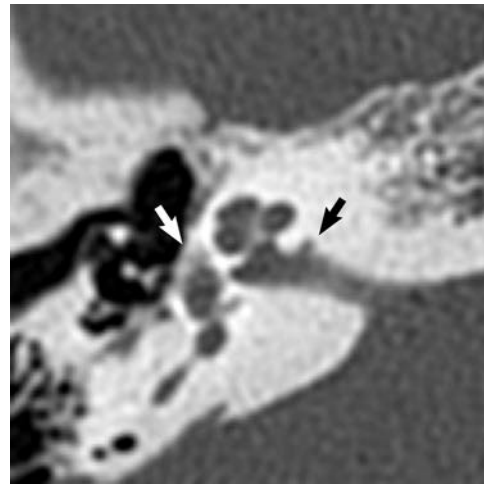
IAC diverticulum with classic imaging findings of otosclerosis on temporal bone CT in a 34-year-old woman evaluated for mixed hearing loss. There is a small IAC diverticulum along the anterior IAC (black arrow) with focal lucency of the otic capsule adjacent to the anterior oval window near the fissula ante fenestram (white arrow).
